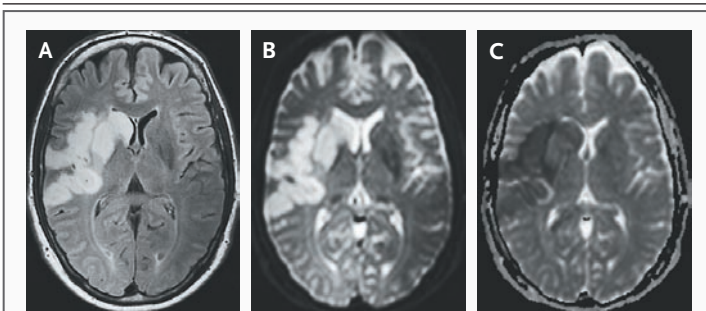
MRI Scans Obtained 2 Days after the Onset of Ischemic Stroke in the Territory of the Right Middle Cerebral Artery.
